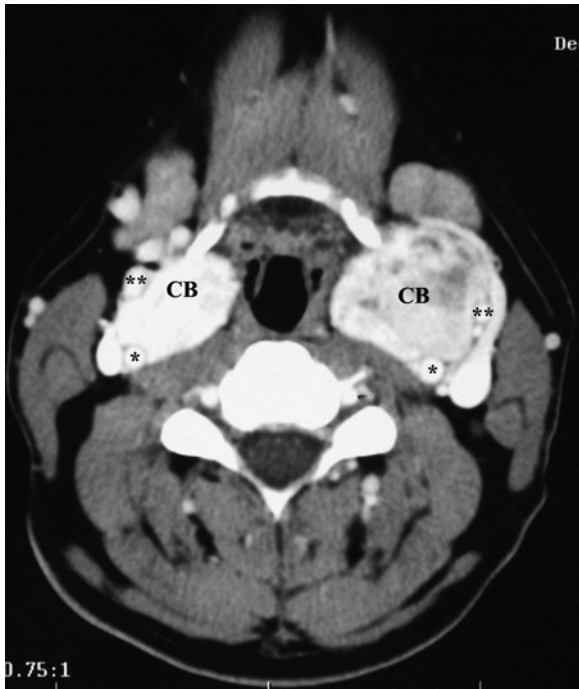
CT of bilateral carotid body tumors. Note the intense enhancement and more homogenous appearance in comparison to the MRI in Fig. 40.6. *CB* carotid body tumors, *asterisk* internal carotid artery, *double asterisk* external carotid artery
